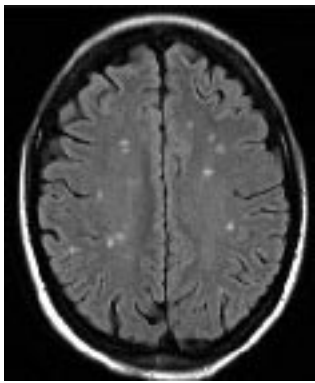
MRI (T2w/FLAIR) of the centrum semiovale showing multiple foci of subcortical signal enhancements which are characteristic but not specific for vasculitis.
